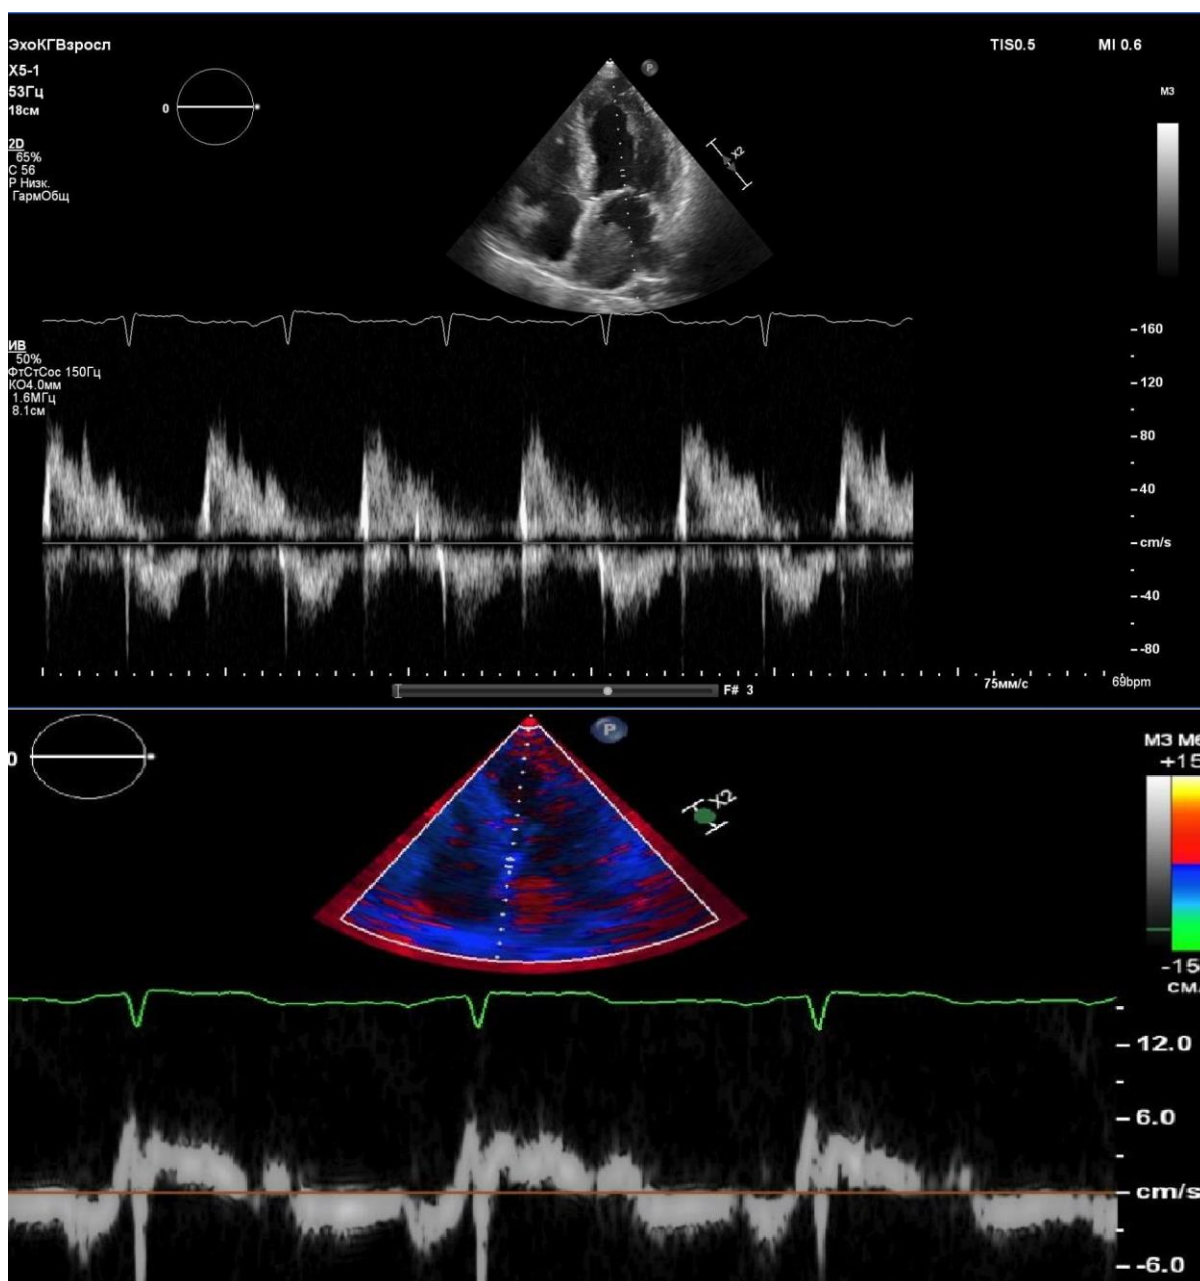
Upper part of the figure- transmitral flow, pulsed wave Doppler. Lower part of the figure- tissue Doppler image of restrictive pattern of transmitral and mitral annular flow.
